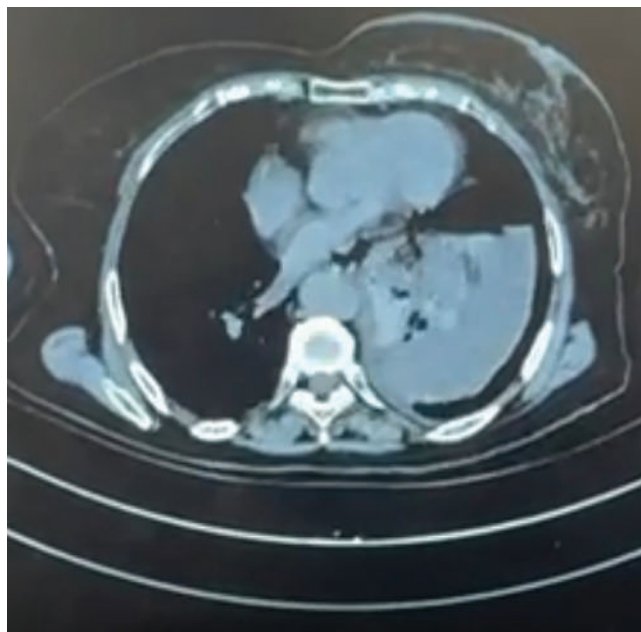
CT image; hiatal hernia and mediastinal free air and fluid.
